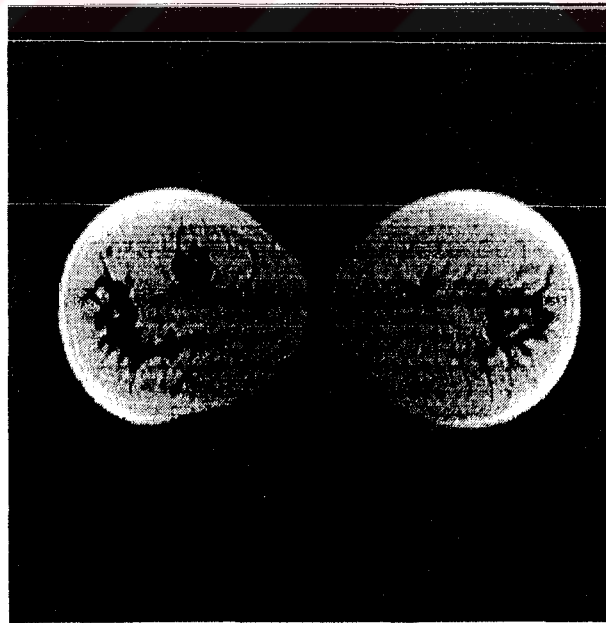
A 2-D section of an MRI image of a female breast.
